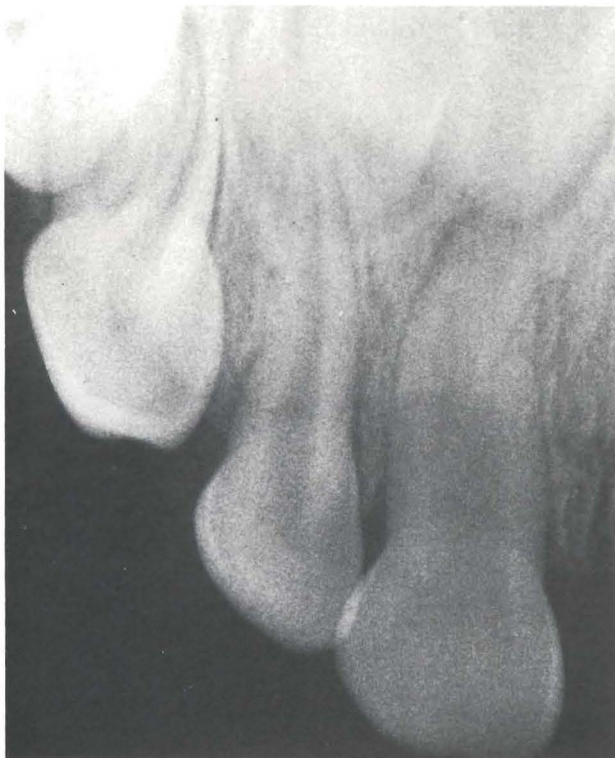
Upper anterior occlusal radiograph showing primary maxillary bilateral birooted cuspid.
